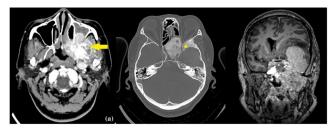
(A & B) CT brain showed heterogenous enhancing lesion (arrow) arising within left sphenoid bone. Presence of area of sclerosis (\*) and thickening within the sphenoid bone noted. (C) On MRI the lesion extended into the intracranial fossa causing mass effect and midline shift.
